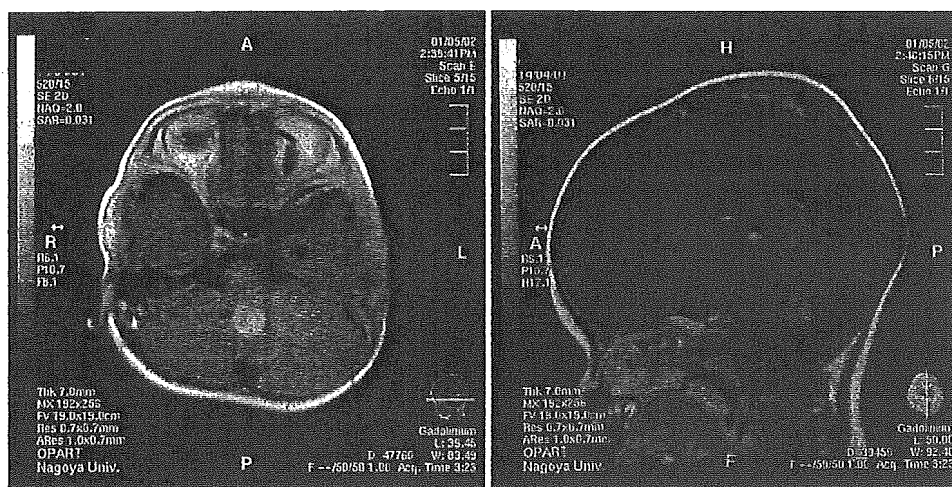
Preoperative enhanced MR image of the brain demonstrating a fourth ventricular tumor with mass effect.
